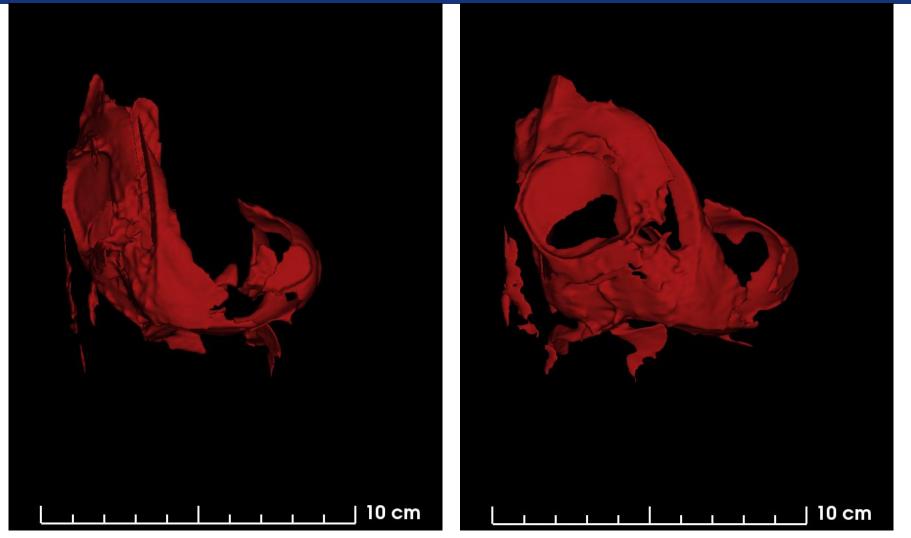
Final three-dimensional MRI reconstructed effusion model. Views from (A) antero-lateral and (B) anterior aspects of the knee
